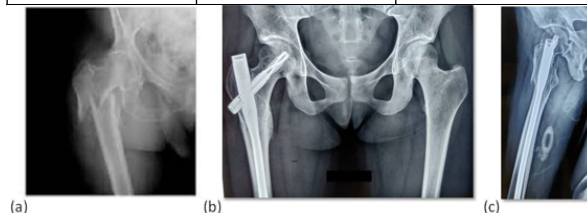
Radiographs of a 23-year-old female patient with closed subtrochanteric fracture: (a) pre-operative radiograph AP view, (b) postoperative radiograph AP view at one-year of follow-up, and (c) postoperative radiograph in lateral view at one-year of follow-up
